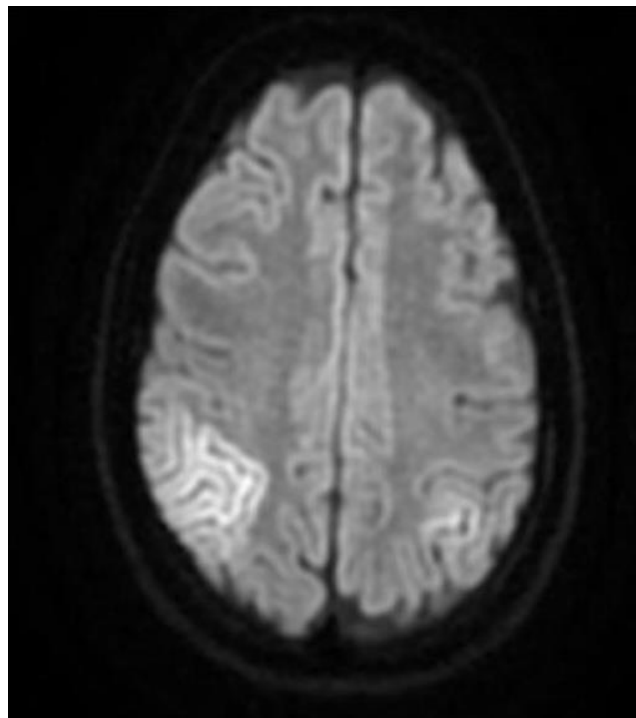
The second MRI of the brain.
